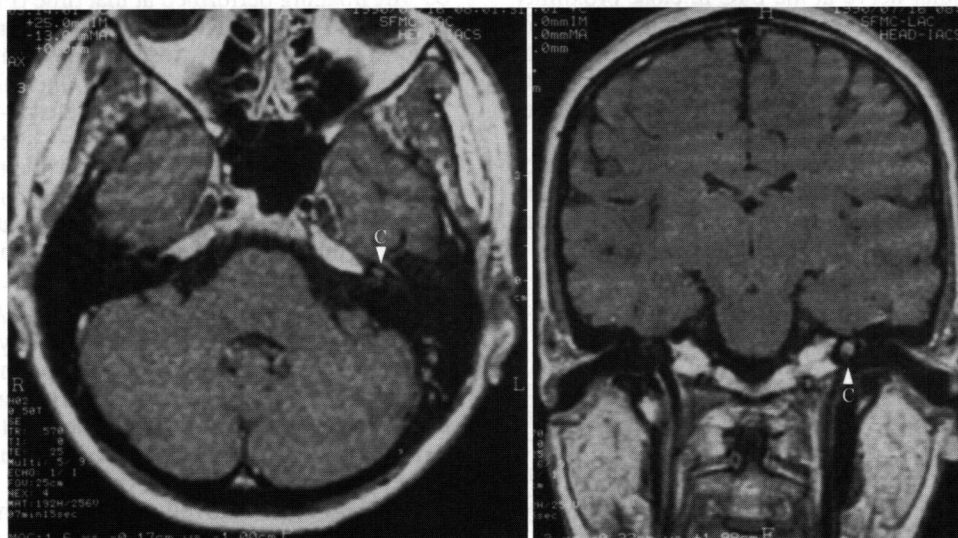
Magnetic resonance images obtained 12 years before diagnosis. Although the results were reported to be normal, axial (left) and coronal (right) postcontrast images demonstrate a small enhancing lesion in the left cochlea (C).
